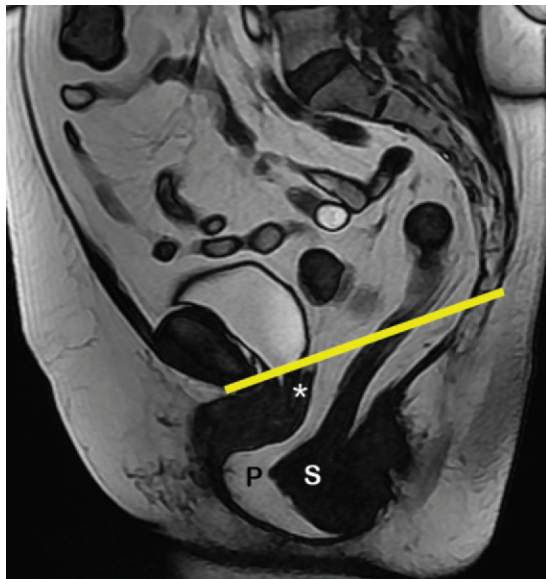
Peritoneocele and sigmoidocele in a 64-year-old woman with a bulging perineal mass and a history of hysterectomy. Midsagittal FIESTA MR image obtained while the patient performed the Valsalva maneuver, without US coupling gel in the rectum, demonstrates a severe peritoneocele (*P*) and anteroinferior prolapse of the sigmoid colon (*S*) with a resultant sigmoidocele compressing the distal part of the anorectum. Caudal angulation of the levator plate and a mild prolapse of the vaginal apex (*) beneath the PCL (yellow line) also are seen. Detection of the high-grade sigmoidocele allowed simultaneous colonic resection and obliteration of the cul-de-sac in a single surgical procedure.
